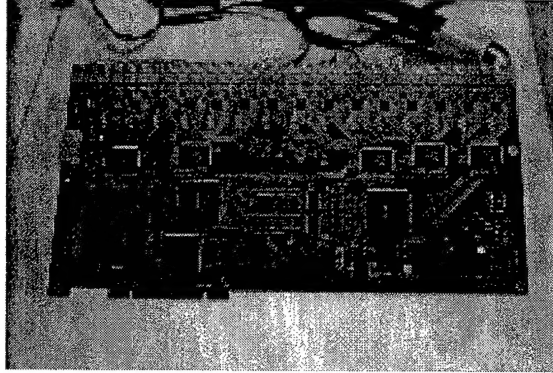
Photo of the data acquisition card that will be used to estimate ultrasonically generated strain, which may induce tumor oxygenation changes
